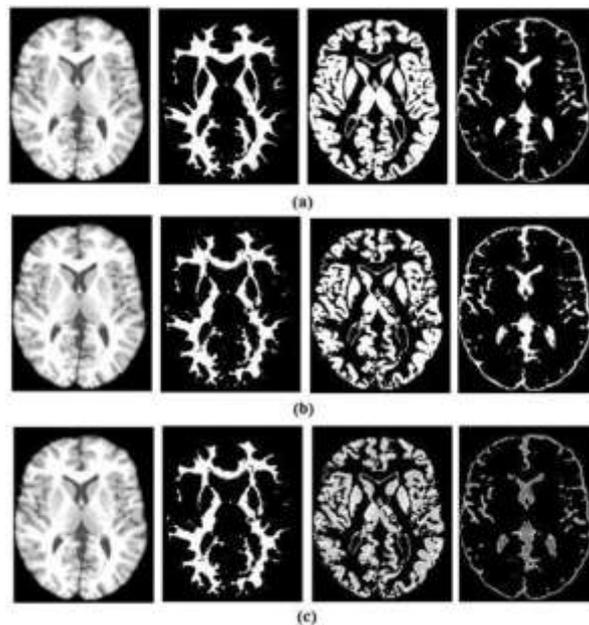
From left to right, original brain MR image, white matter, gray matter and cerebro-spinal fluid (a) discrete anatomical model of the original image, (b) binary segmented image of the proposed method (c) gray level segmented image of the proposed method
